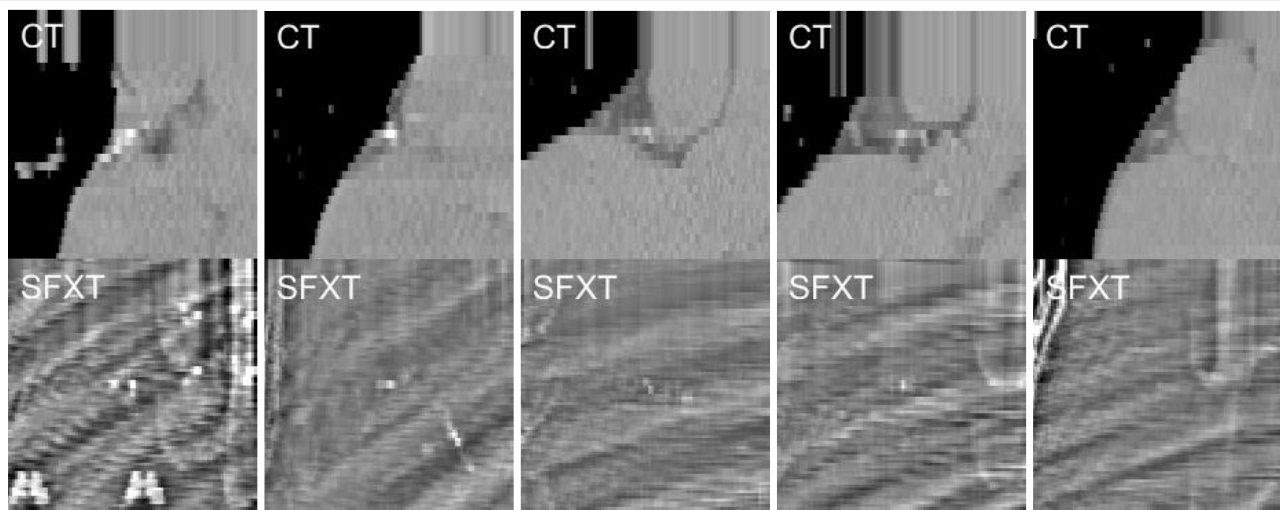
Five examples of coronary calcification with different severities. Each column corresponds to a distinct cases with CT on top and dual-energy SFXT on bottom. The left cases have more calcium than the right cases. From left to right, the calcium scores corresponds to calcium scores of 925, 734, 366, 124, and 10. The ACC/AHA guidelines describe abnormal CAC levels to be in excess of 300 points (2), at which point statin therapy could be initiated for intermediate-risk patients. [WL, WW] = [0, 600] HU for CT images.
